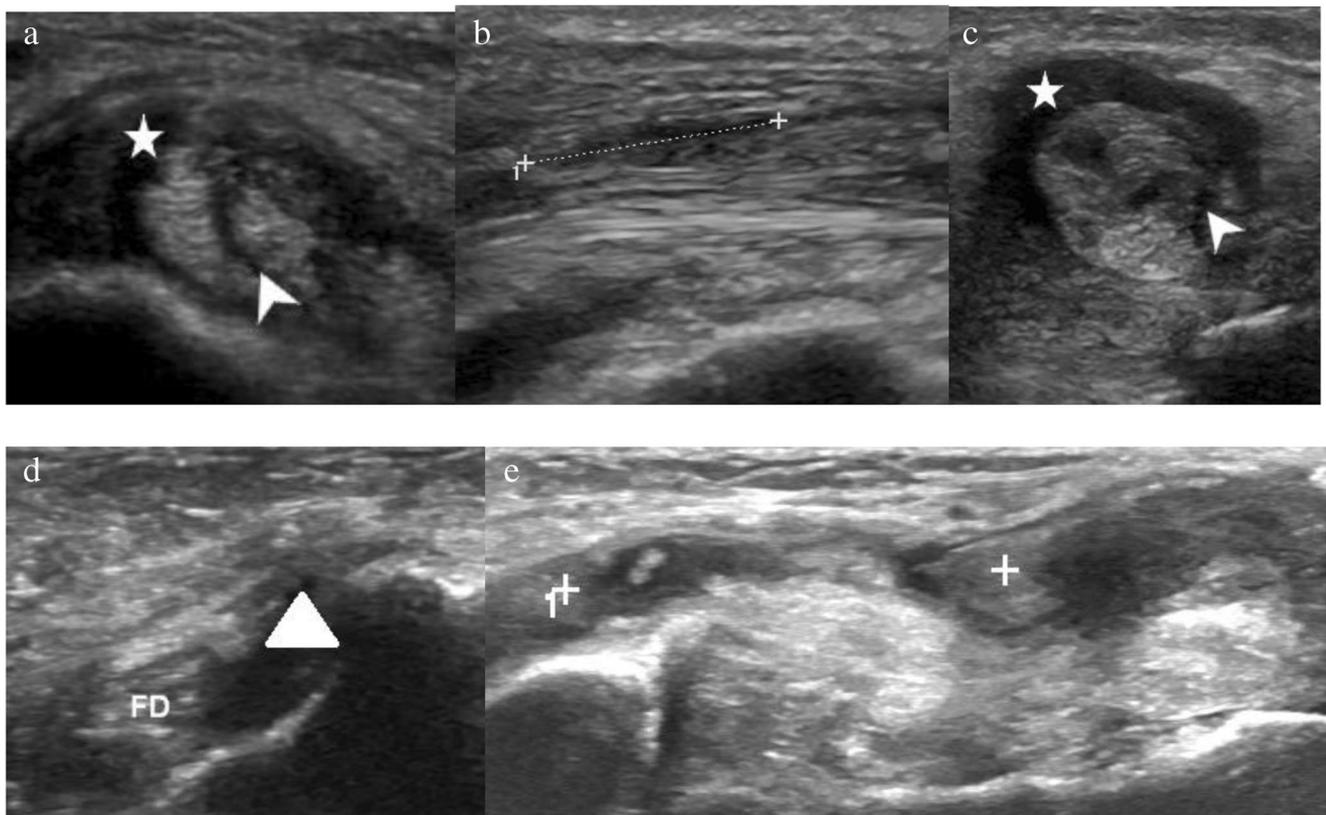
Ultrasound images of longitudinal split, partial-thickness, and full-thickness tears of the PTT. a Short- and b long-axis ultrasound images in a 77-year-old man demonstrating a PTT longitudinal split tear. The split tear is noted by the *arrowhead* on the short-axis image and the caliper measurement on the long axis image. Tenosynovitis is noted by the *star* on the short-axis image. c In another 69-year-old woman, posterior tibial tendinosis, tenosynovitis (*star*) and an intrasubstance partial-thickness
